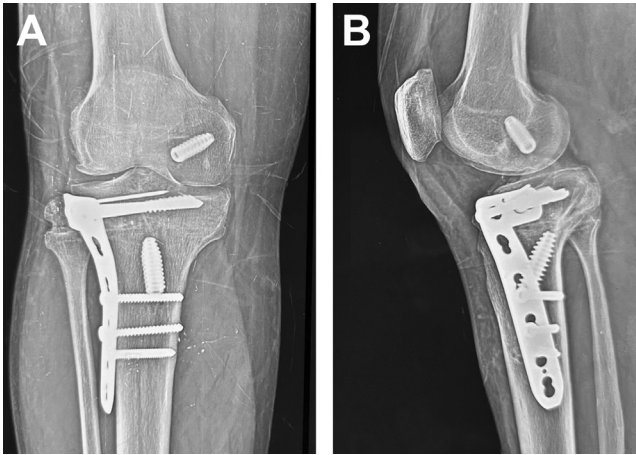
X-rays of the right knee. (A) Anteroposterior and (B) Lateral views. On presentation showed implants of a lateral closed-wedge high tibial osteotomy and posterior cruciate ligament reconstruction.
